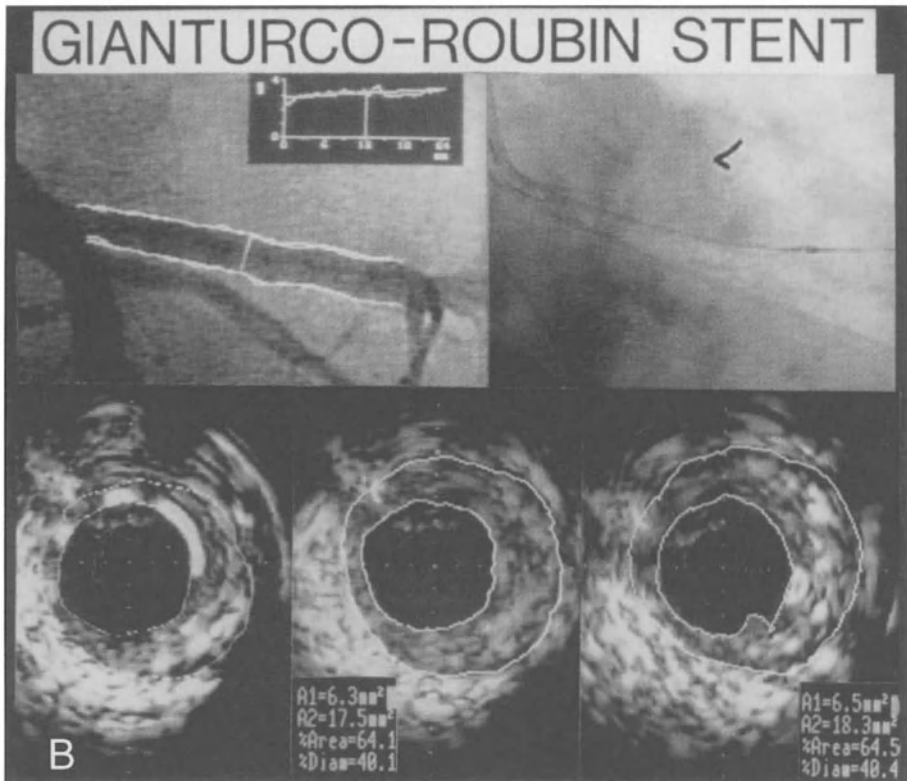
B) Digital angiogram showing a regular lumen after implantation of a Gianturco Roubin stent in a proximal left anterior descending coronary artery. The stent is barely visible in the fluoroscopic image obtained during the ultrasound examination but the circumferentially arranged metallic wires of the stent show a high echogenicity with ultrasound. Note that an eccentric residual plaque is shown despite the regular circular lumen (echographic images on the right), with a small protrusion of the plaque tissue through the wires of the stent. Calibration: 0.5 mm.
